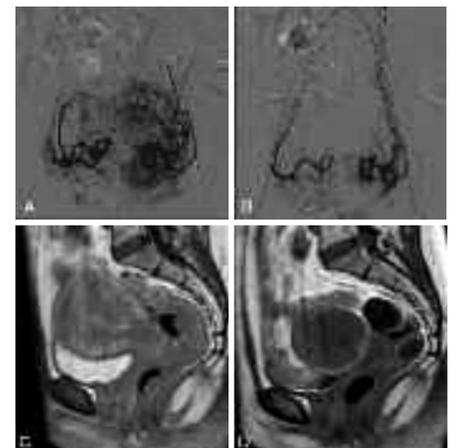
UAE in a woman with pure adenomyosis. (a) Frontal angiogram with contrast injection of both uterine arteries demonstrating the vascularisation of adenomyosis with deep penetrating parallel arterioles. (b) Frontal angiogram after UAE with the proper embolisation end-point. (c) Sagittal contrast enhanced T1 weighted MRI of pure adenomyosis before UAE. (d) Sagittal contrast enhanced T1 weighted MRI 3 months after UAE demonstrating complete infarction of pure adenomyosis with uterine volume reduction.
